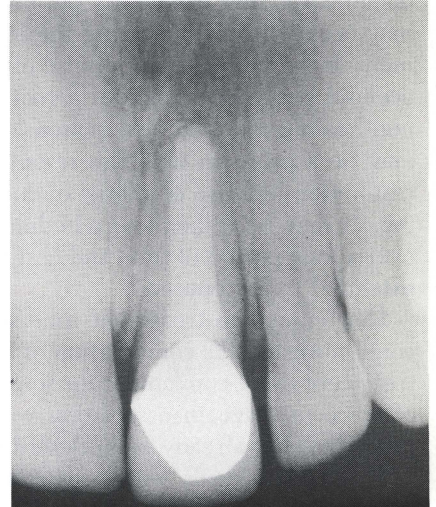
Radiograph at ten years post-filling, showing normal periapical tissue.
